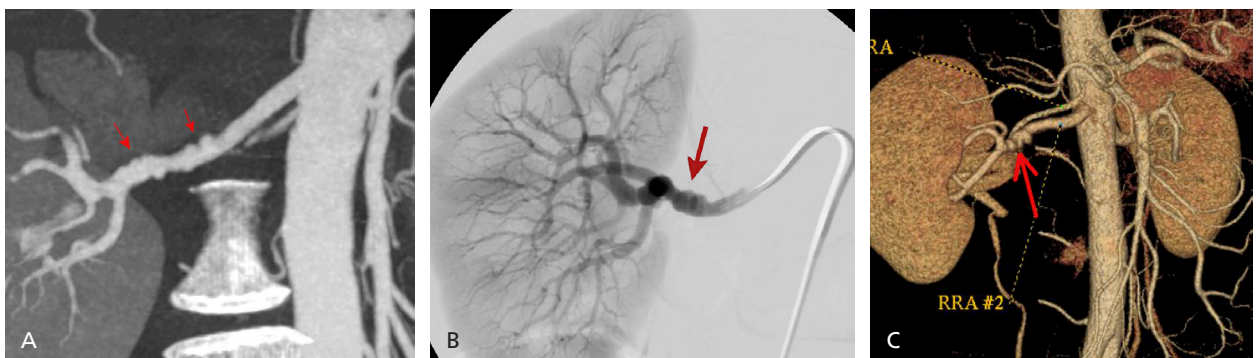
Fibromuscular dysplasia. Computed tomography angiography shows the “string of beads” appearance of fibromuscular dysplasia in the typical distribution of the distal two-thirds of the main renal artery. Images from (A) subvolume maximal intensity projection, (B) digital subtraction angiography, and (C) three-dimensional volume-rendered display.
